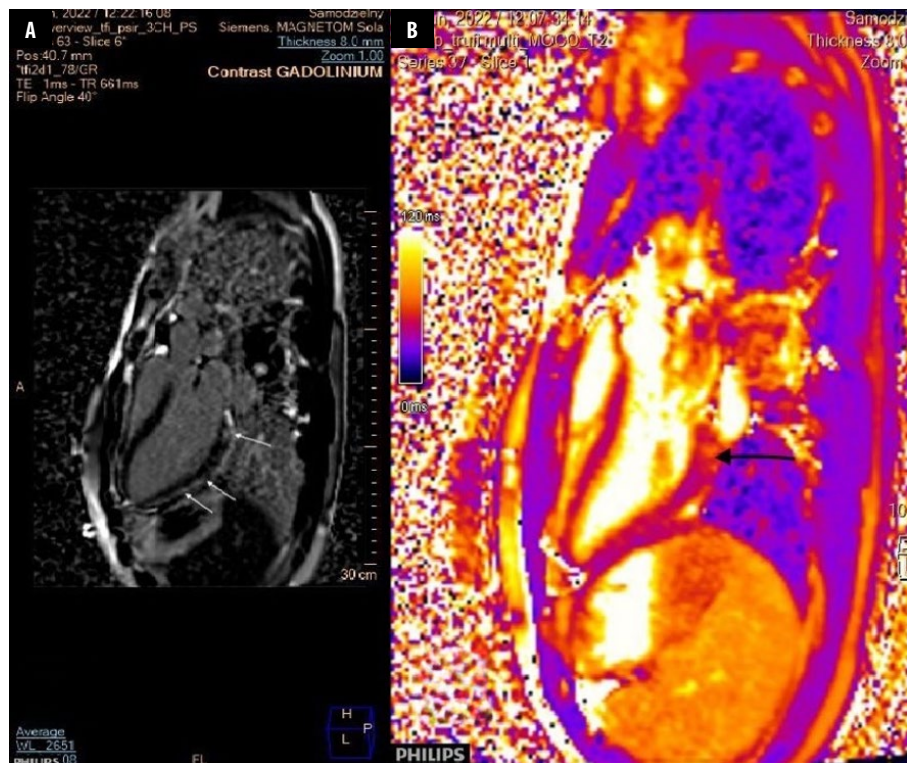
A. Cardiac MRI of myocarditis after the third dose of COVID-19 vaccine. T2 mapping demonstrates oedema in basal infero-lateral segment (arrows). B. Phase-sensitive inversion recovery (PSIR) image shows the area of late gadolinium enhancement (LGE) located in the basal, middle infero-lateral, and apical lateral segments of the left ventricle (arrows)
